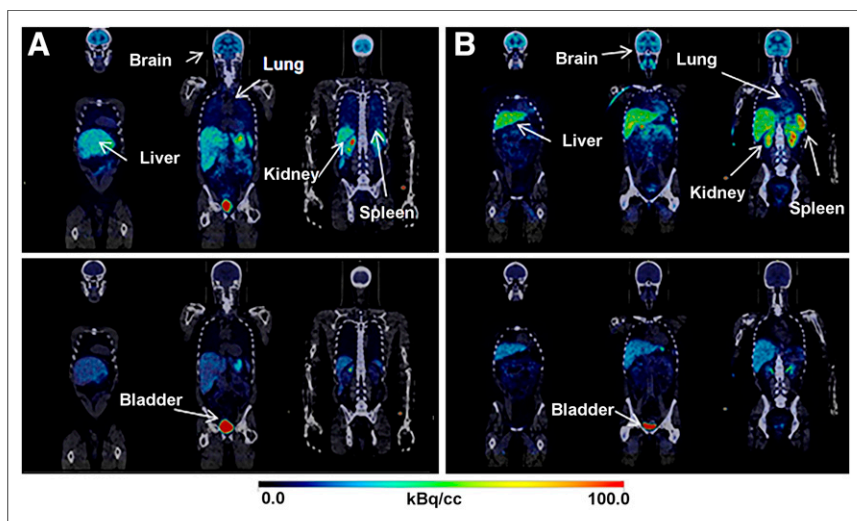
Coronal view of representative 2.8-min (top) and 22.6-min (bottom) whole-body PET/CT images of man (A) and woman (B). Early images clearly delineate brain, liver, spleen, lungs, and kidneys. Late images show intense accumulation in urinary bladder. Brain, liver, lungs, spleen, and kidneys are less conspicuous in late images than in early images, indicating significant washout of radioactivity from these organs with time.
